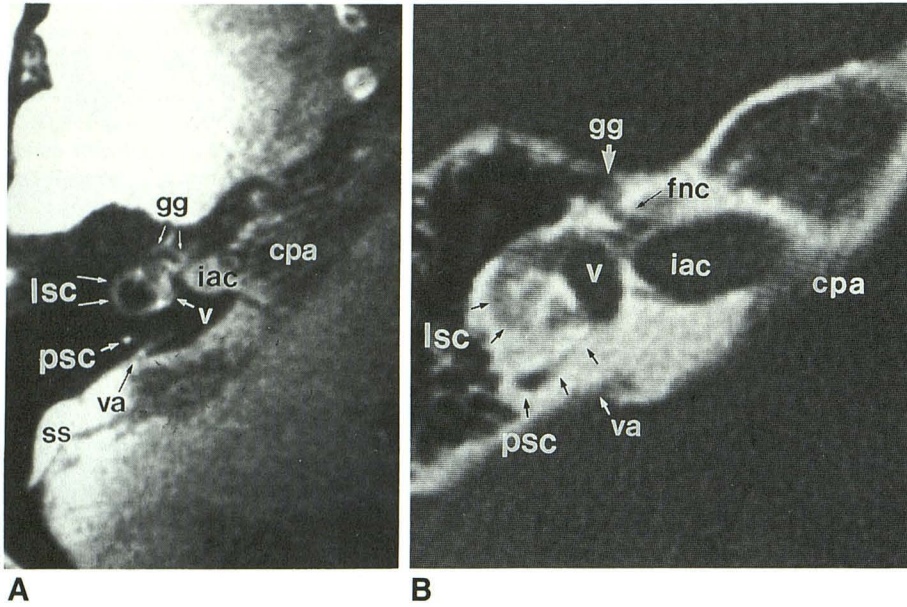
A, Axial 3DFT MR image at level of right lateral semicircular canal. Lateral semicircular canal (lsc) is seen as semicircular high-signal focus. Anteriorly, inverted V-shaped proximal and distal limbs of geniculate ganglion (gg) are seen. Posteriorly, endolymphatic duct and sac within vestibular aqueduct (va) course parallel to posterior semicircular canal (psc). Note higher signal from CSF within lumen of the internal auditory canal (iac) compared with that of adjacent cerebellopontine angle (cpa), a finding that suggests relative stasis.
